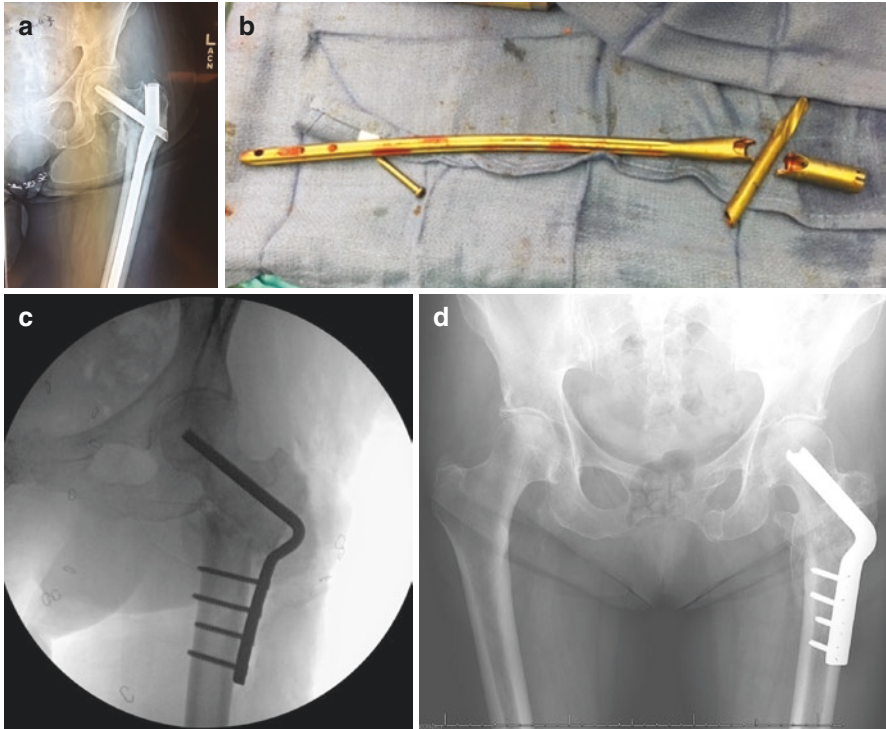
An 80-year-old female who is one year status post treatment of a pertrochanteric hip fracture with a long IM Nail. (a) AP radiograph demonstrating fracture nonunion with hardware failure. (b) Intraoperative photo demonstrating nail failure at the lag screw hole. (c) AP intraoperative radiograph following osteotomy and nonunion repair with a blade plate. (d) AP pelvis radiograph at 1 year following nonunion repair. There is complete union and an excellent clinical result
